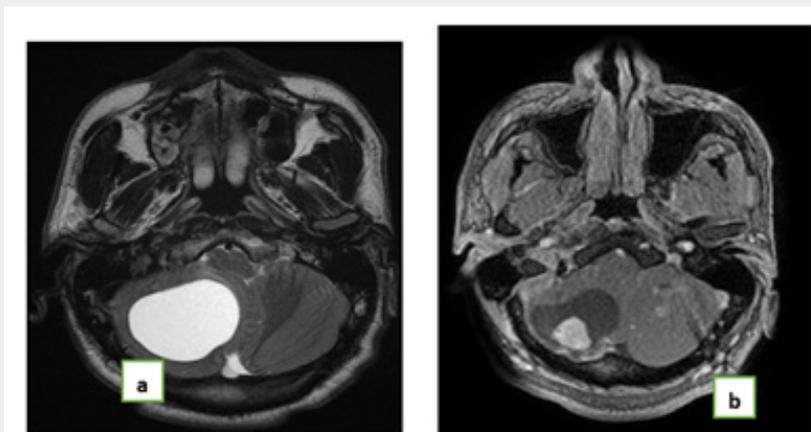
Cerebral MRI; sagittal cut T1 (a), axial T2 (b) and T1 after injection of Gado (c) showing voluminous solid-kystic cerebellar mass right with a wall nodal that rises intensely after injection in relation to a complicated cerebellous hemorrhagic hemangioblastoma of hydro-cephalus, which fits into the context of the disease of von Hippel. mangioblastome c.
